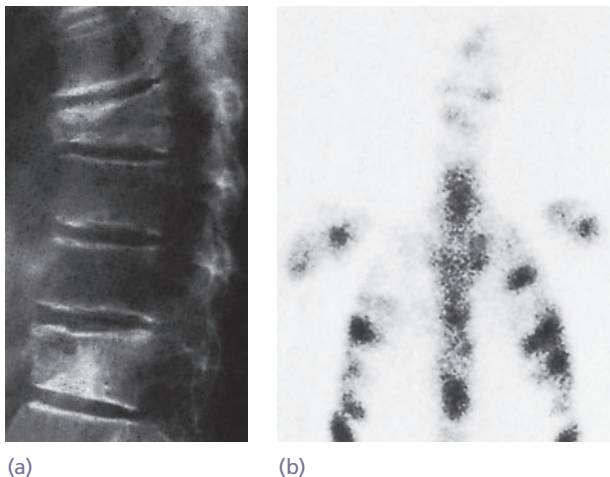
Radionuclide scanning (a) The plain X-ray showed a pathological fracture, probably through a metastatic tumour. (b) The bone scan revealed generalized secondaries, here involving the spine and ribs.
